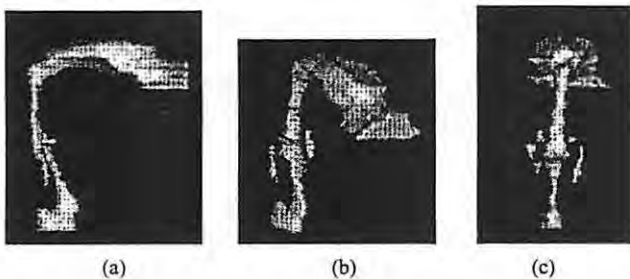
Shaded surface displays of the vowel /a/ using the MR image set: a, b, and c) various projections of the airway.
